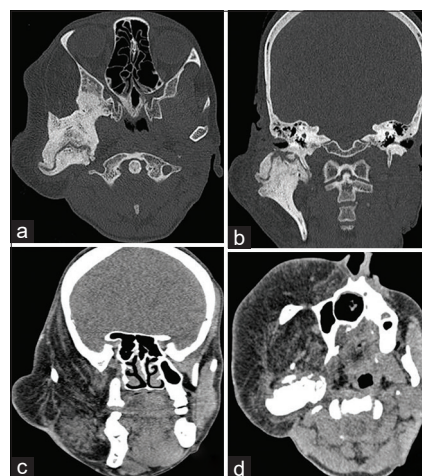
(a) Axial and (b) coronal computed tomography images (bone algorithm) show marked expansion with new bone formation, remodeling with articular surface irregularity of the right condylar head and temporal bone forming the glenoid fossa with the right temporomandibular joint ankylosis. There is an expansion with sclerosis of the right greater wing of the sphenoid bone and (c) coronal and (d) axial computed tomography images (soft tissue window) show fatty infiltration of the right side of the cheek, masticator space, buccal space, parotid gland, masseter, medial and lateral pterygoid muscles, upper lip, and right half of the tongue
